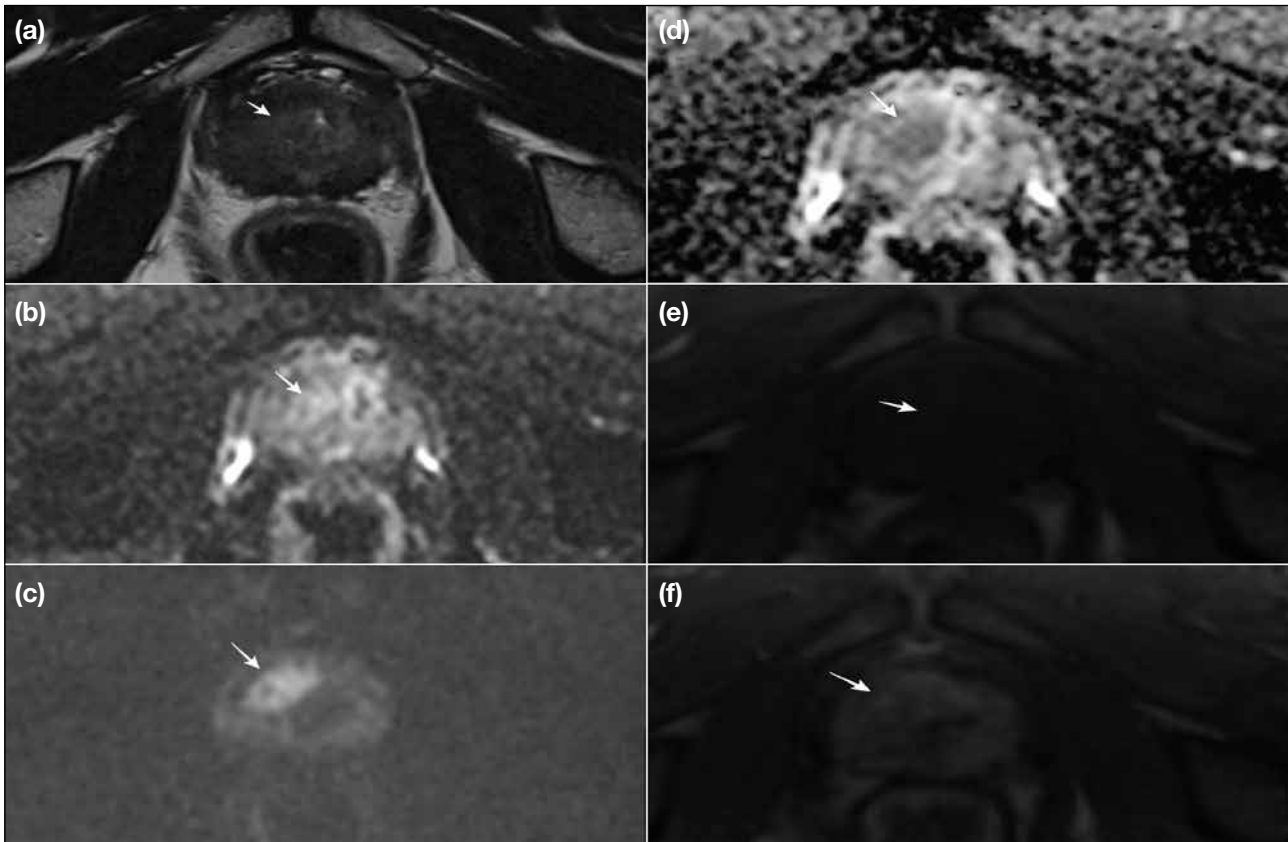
A 67-year-old man with prostate-specific antigen level of 8.31 ng/mL. Arrows indicate a Prostate Imaging Reporting and Data and System (PI-RADS) category 5 lesion visible in the peripheral zone. (a) Axial T2-weighted magnetic resonance (MR) image showing the lesion in the right apex/peripheral zone. The diameter of the lesion is 2.0 cm, which is consistent with a PI-RADS score of 5 on T2-weighted imaging. (b and c) show that the lesion is hypointense on diffusion-weighted imaging (DWI) [$b = 50 \text{ s/mm}^2$] and hyperintense on DWI ($b = 1800 \text{ s/mm}^2$). (d) Apparent diffusion coefficient map indicates that the lesion is significantly hypointense, giving it a PI-RADS score of 5 on DWI. (e) Pre-contrast T1-weighted and (f) dynamic contrast-enhanced MR images show early enhancement within the same location as the lesion in (a-d) with early enhancement for overall PI-RADS version 2.1 score of 5. Transrectal ultrasound-guided cognitive imaging fusion biopsy detected prostate cancer with International Society of Urological Pathology score of 5.
